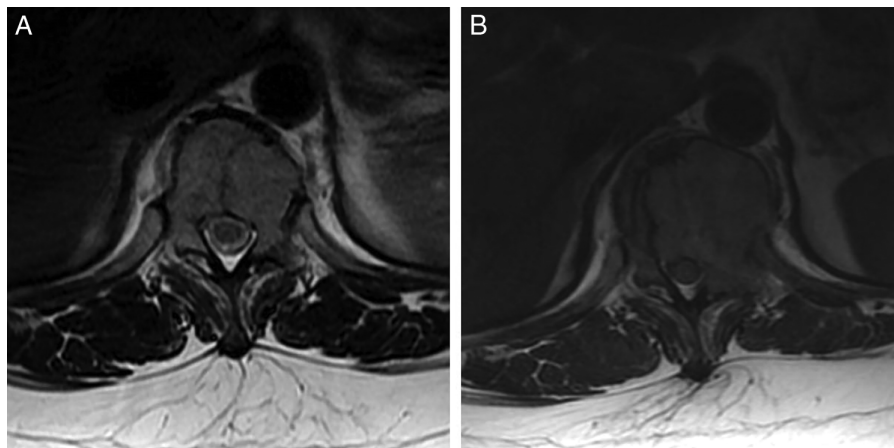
Axial T2 weighted MRI of the spine in a 48-year-old woman with metastatic pancreatic cancer. A, On her initial MRI, the metastatic tumor displayed grade 1a epidural spinal cord compression (ESCC) that progressed to B, ESCC grade 3 on a subsequent MRI 4 months later and Spine Instability Neoplastic Score consistent with mechanical instability.
